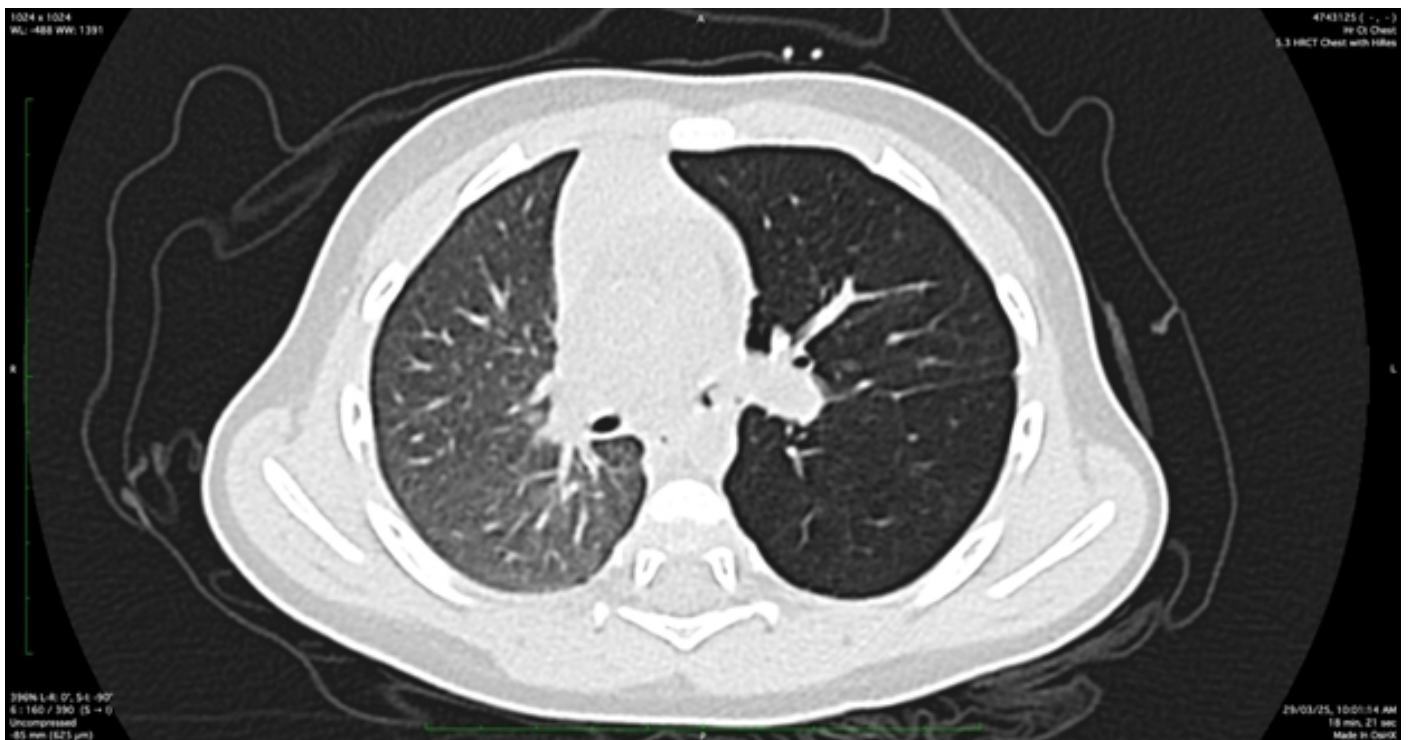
CT Chest showing Foreign Body in Left Main Bronchus
